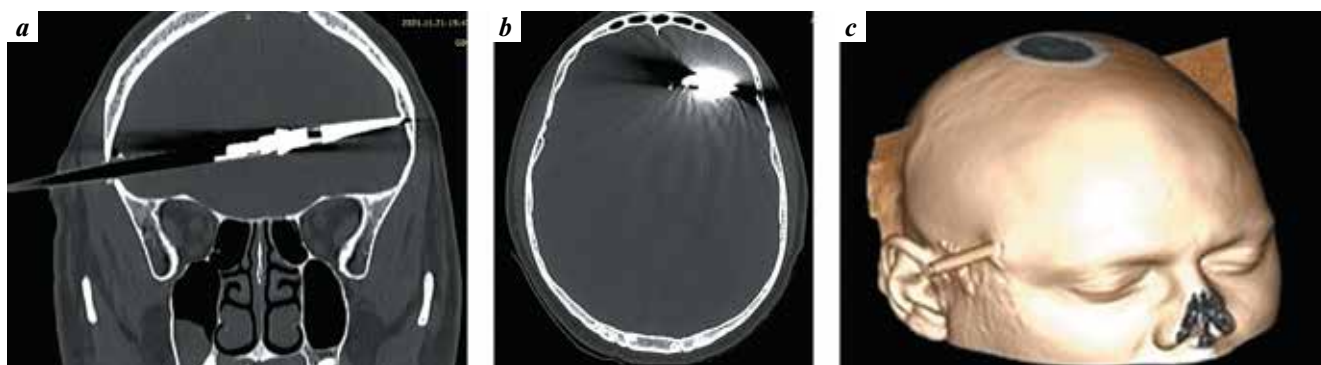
Computed tomography of patient N. at admission: a – frontal projection: arrowhead at the inner plate of the frontal bone; b – axial projection; c – 3D reconstruction
